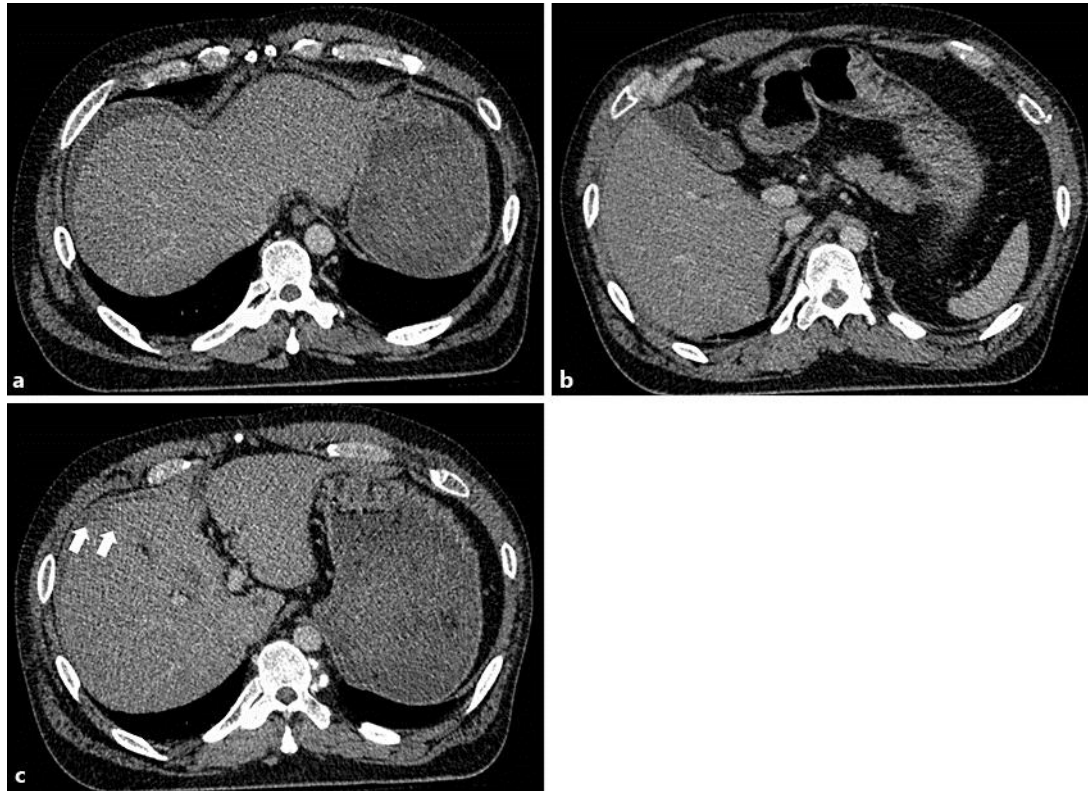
a Enhanced abdominal CT on admission revealing hemorrhagic accumulation around the liver. b No apparent abnormal gallbladder findings were observed, but a costal cartilage fracture was seen. c Liver laceration was suspected (arrows).
